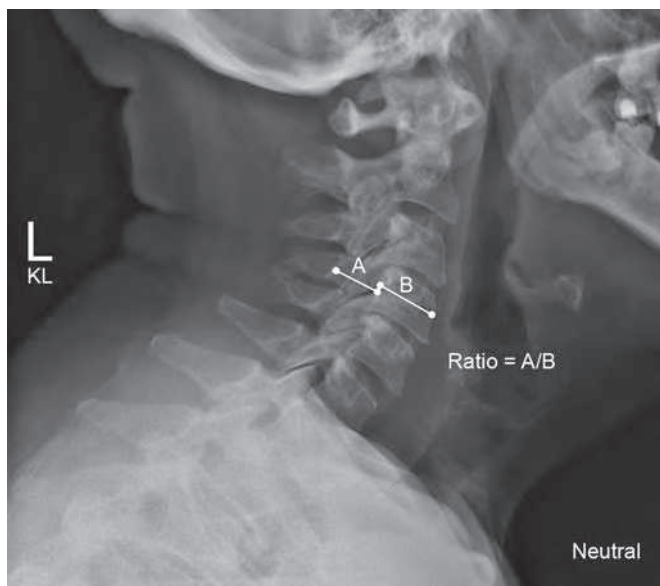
Lateral X-ray of the cervical spine demonstrating the Pavlov, or Torg, ratio measurement.
